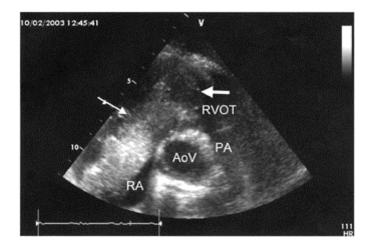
Transthoracic short-axis view of the base of the heart. Uterine leiomyoma originating from inferior vena cava obstructs tricuspid valve (thin arrow) and impedes right ventricular filling and right ventricular outflow (thick arrow). AoV: aortic valve; RA: right atrium; RVOT: right ventricular outflow tract; PA: pulmonary artery.
